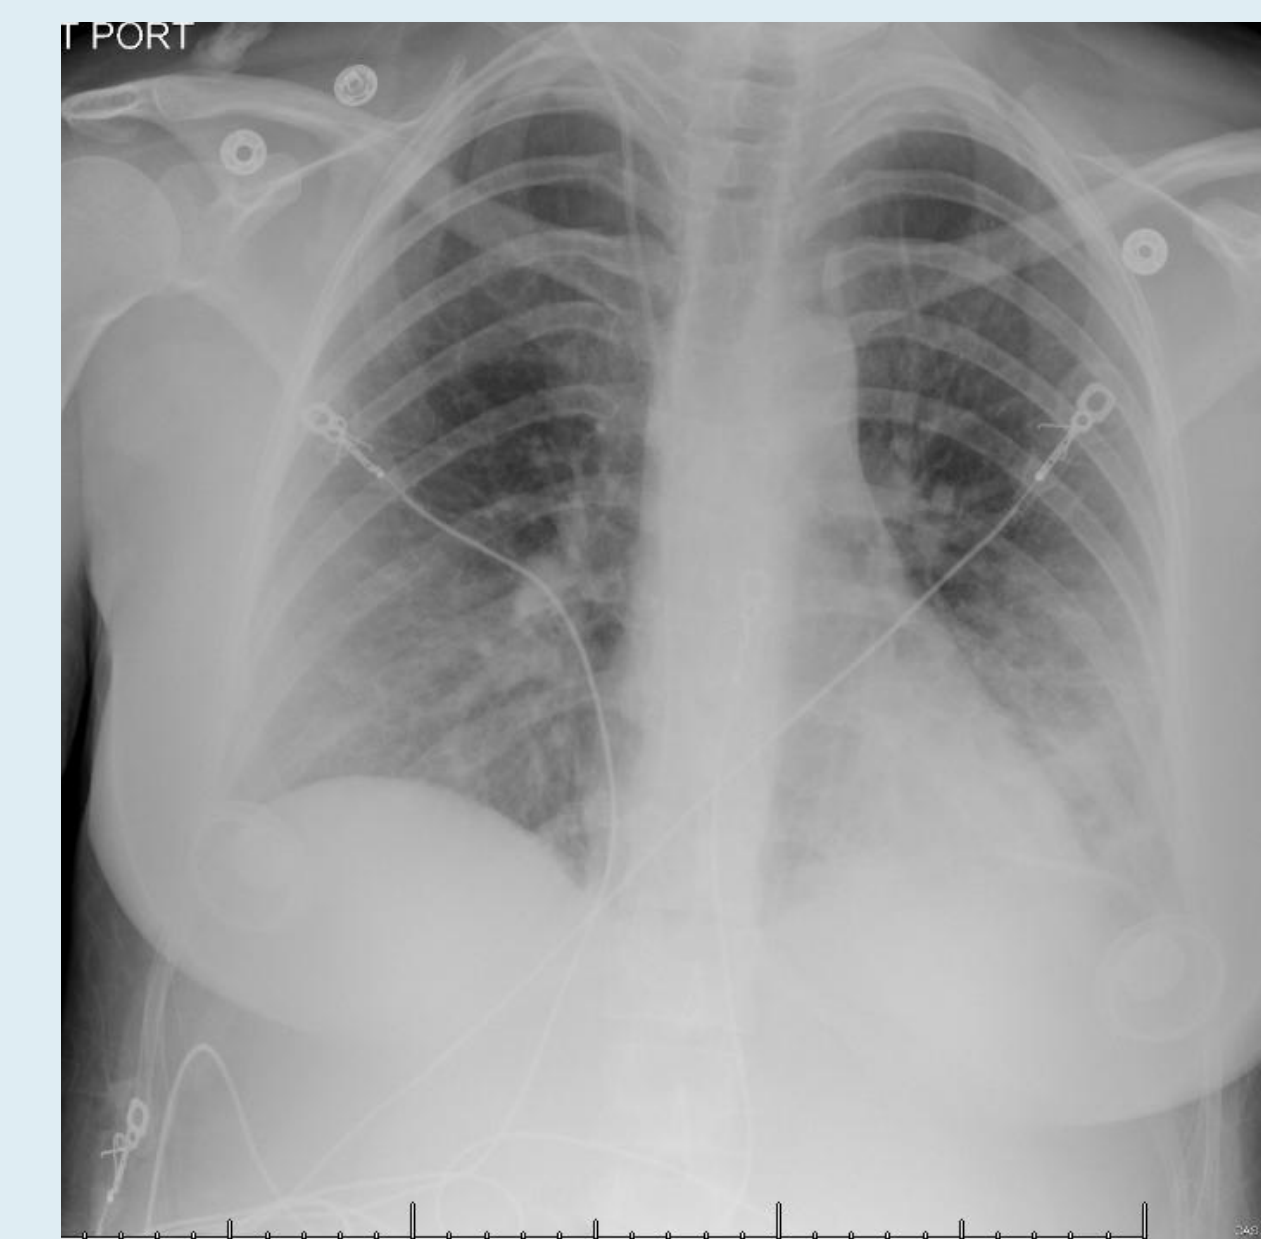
Chest X-ray showing development of LLL consolidation
